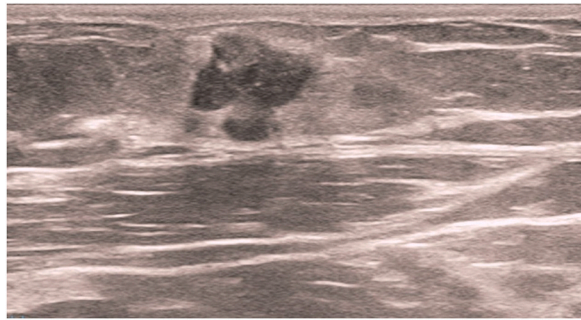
Ultrasonic image.
